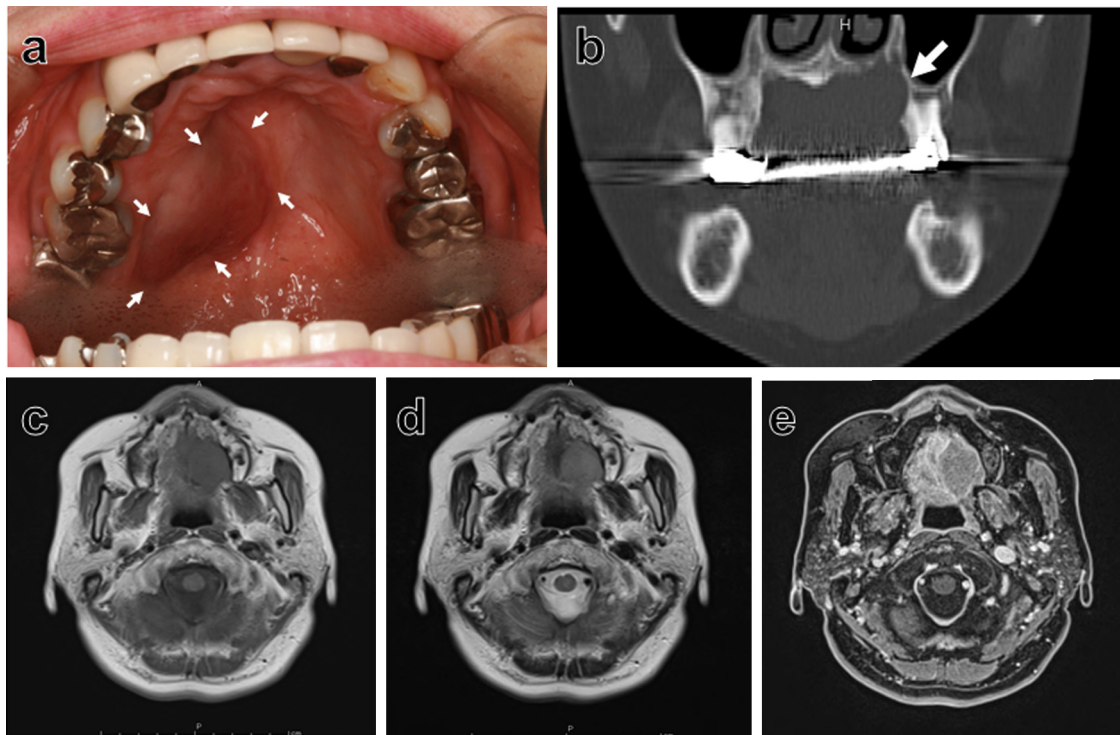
Case images and clinical findings. (a) Clinical photograph of the left palatal tumor reflected in the glass. (b) Computed tomography image showing a homogeneous lesion and pressure bone resorption by the tumor (arrow). (c–e) Enhanced magnetic resonance image of the lesion. (c: T1 weighted image; d: T2 weighted image; and e: diffusion weighted image).
